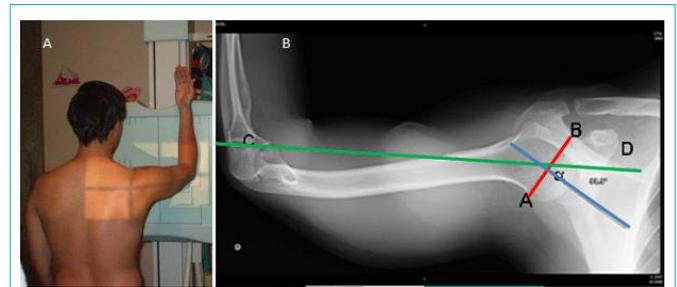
X-Ray Experimental set-up (A) and a semi-axial radiograph positioning (B) with reference lines used for the humeral retroversion angle calculation (see text for details).
